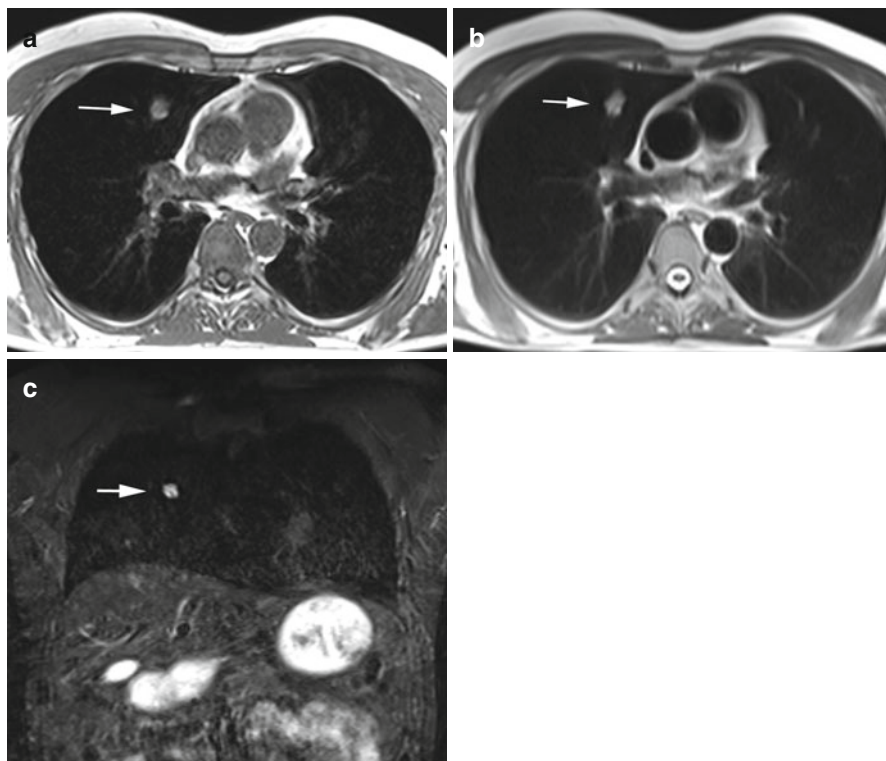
Primary lung cancer in a 56-year-old male subject. Images demonstrate a solitary pulmonary nodule (20×14 mm) in the right middle lobe (a–c). Invasive diagnostic workup with CT-guided core biopsy yielded the diagnosis of primary lung cancer without nodal or parenchymal metastasis
